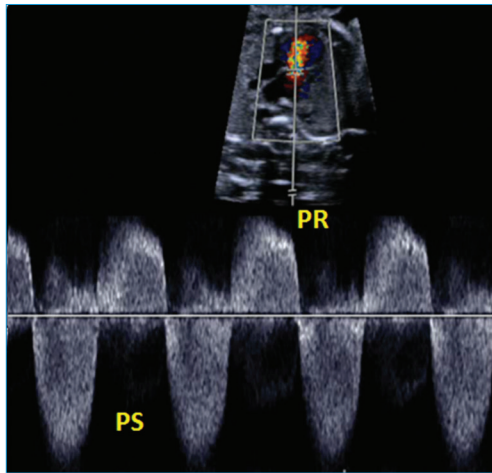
Doppler spectral in the pulmonary valve shows the pulmonary stenosis and pulmonary regurgitation Doppler pattern
